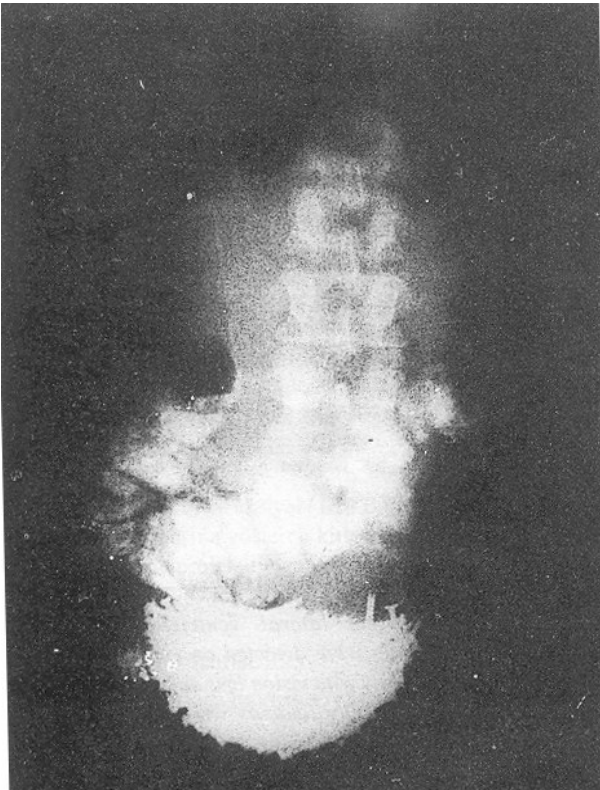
Metallic foreign bodies seen on the abdominal X-ray.
